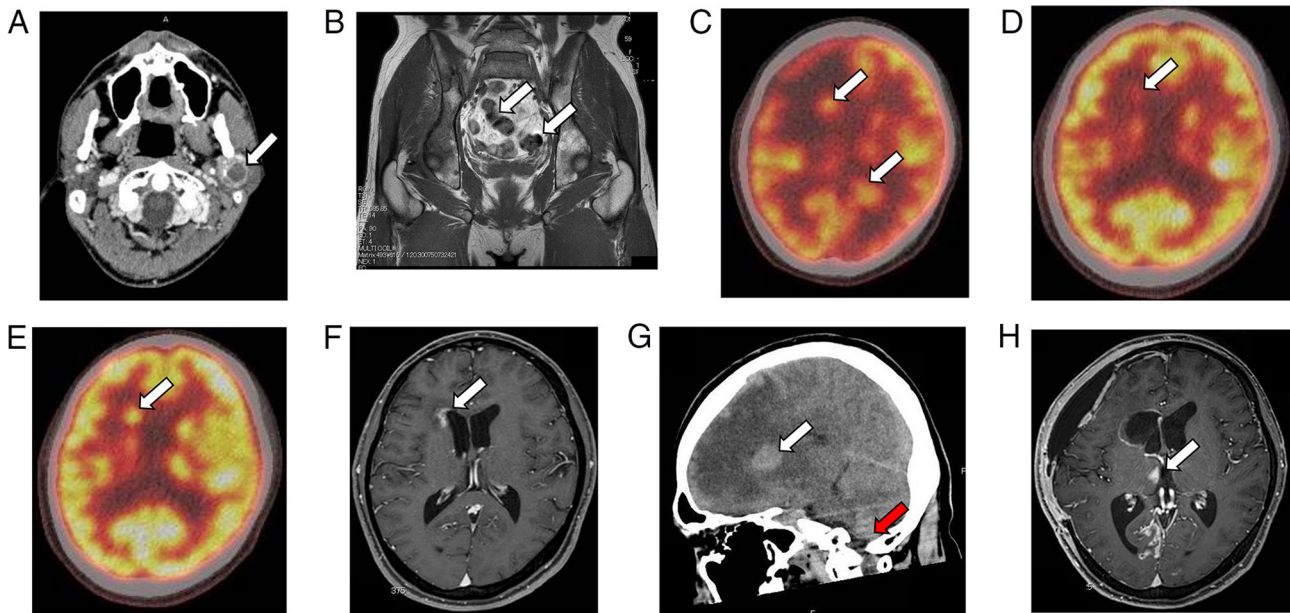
Imaging findings. (A) Contrast-enhanced CT revealing the presence of an ill-defined and irregularly shaped mass predominantly involving the deep lobe of the left parotid gland (arrow). (B) MRI scan showing metastatic lesions in the iliac bone (arrows). (C) PET scan demonstrating metastatic lesions in the brain (arrows). (D) PET scan showing reduced fluorodeoxyglucose uptake in the metastatic lesion in the brain (arrow). (E) PET scan demonstrating increased fluorodeoxyglucose uptake in the metastatic lesion in the brain (arrow). (F) MRI scan showing the reduction in size of the metastatic lesion in the brain (arrow). (G) CT scan showing brain oedema around the metastatic tumour (white arrow) and brain herniation (red arrow). (H) MRI scan demonstrating no obvious tumorous lesion in the surgical site, but a new metastatic lesion present in the brain (arrow).
